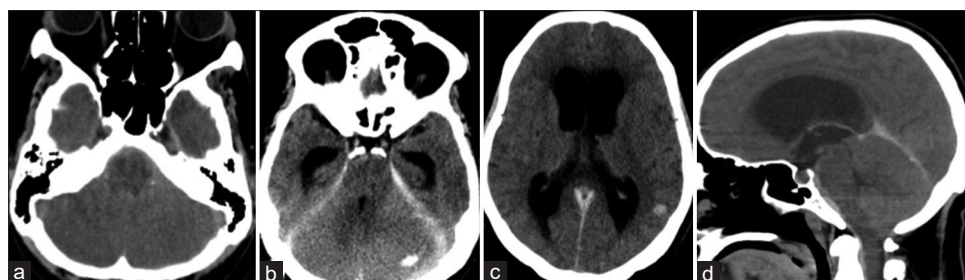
(a-c) Axial sections of computed tomography of brain on day 2 of admission showing effaced basal cisterns with dilated lateral ventricles. (d) Sagittal section of computed tomography of the brain showing crowded posterior fossa components
